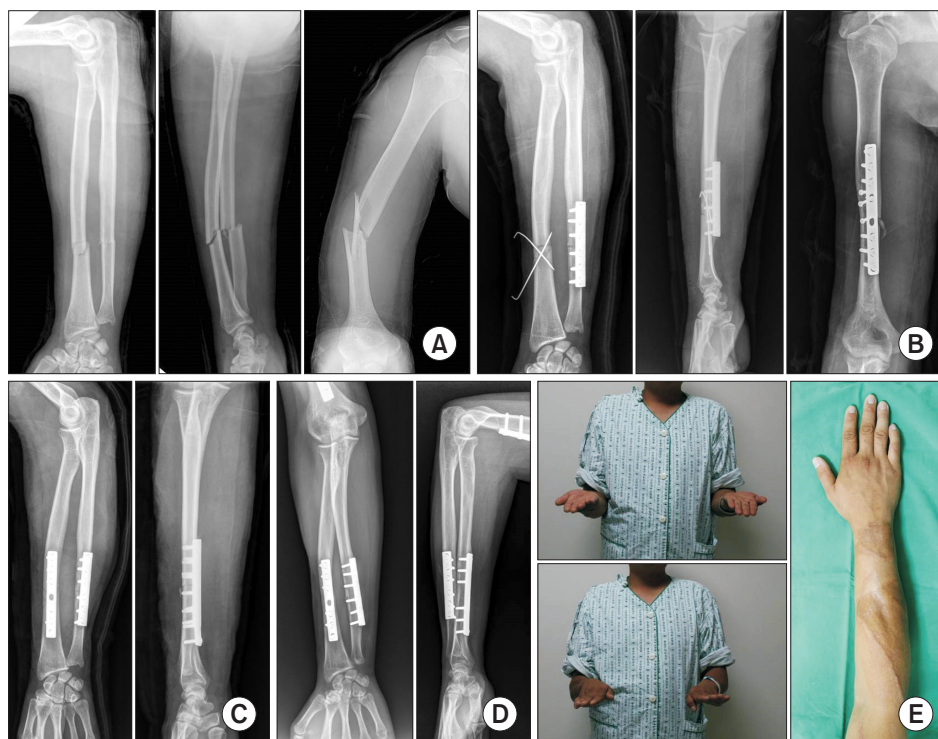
Case 1. (A) A 36-year-old man with shaft fractures of both forearm bones and an ipsilateral shaft fracture of the humerus caused by belt injury during work. (B) Shaft fractures of the ulna and humerus were initially treated with open reduction and internal fixation. But, the radial fracture was temporarily fixed with two Kirschner wires because of swelling and skin abrasion of the right forearm. (C) The radial fracture was stabilized by plating after 9 days. The necrotic tissue due to abrasion of the skin was debrided and a split-thickness skin graft was placed later. (D) Final follow-up radiographs showed union of shaft fractures of the radius and ulna. (E) Clinical photographs showed normal rotation and satisfactorily healed skin of the right forearm at the 24-month follow-up.
